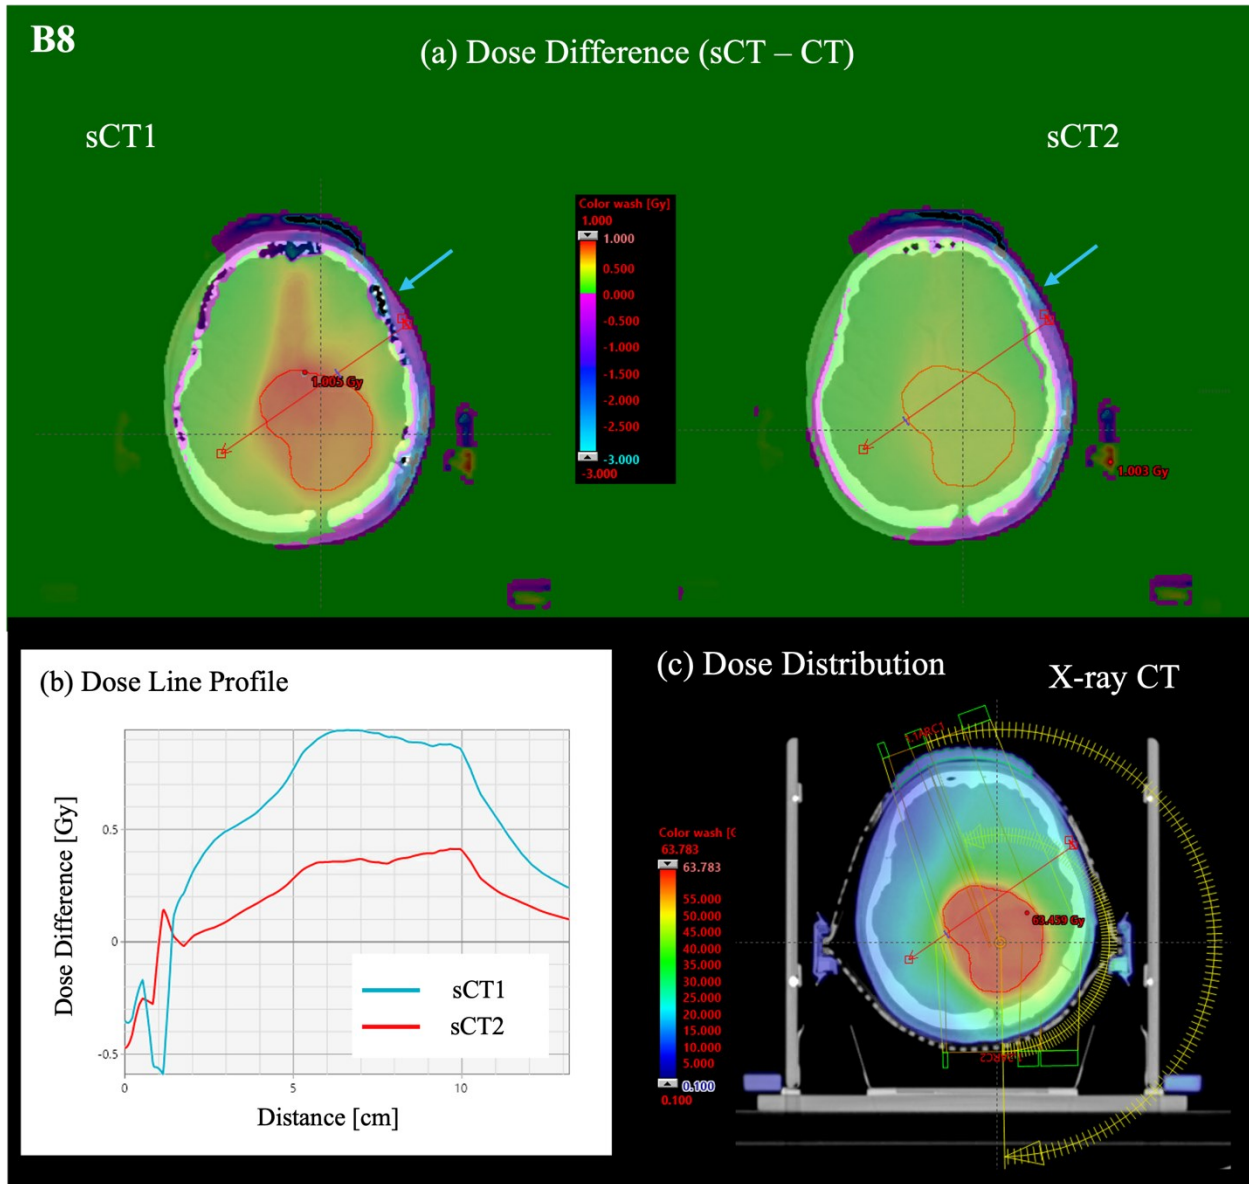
(a) Dose difference maps for sCT1 and sCT2 for patient B8. Regions of corrected bone structures through the modification of the sCT generation method are shown by blue arrows. (b) Line profiles of the dose difference between plans calculated on sCT1 and sCT2 and X-ray CT, respectively, taken along the red line shown on the sCT and X-ray CT images. (c) Dose distribution calculated on the planning CT image.
